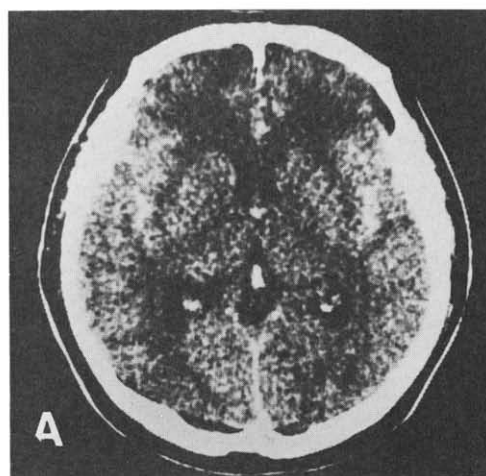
Case 2. (A) Preoperative CT scan showing SAH in bilateral sylvian and interhemispheric fissures. (B) CT scan 1 day after surgery showing no apparent abnormalities except for the persistent SAH and postoperative changes. (C) CT scan 12 days after surgery demonstrating the right subgaleal and epidural hematomas.
